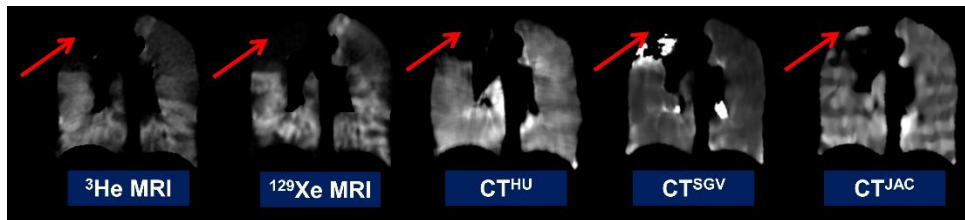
Coronal views of CT^{HU} , CT^{SGV} and CT^{JAC} filtered with a median radius of $3 \times 3 \times 3$ and ^3He and ^{129}Xe MRI after image registration for an example patient. A similar ventilation defect is observed in all three images in the right upper lobe with varying spatial extent (red arrow).
